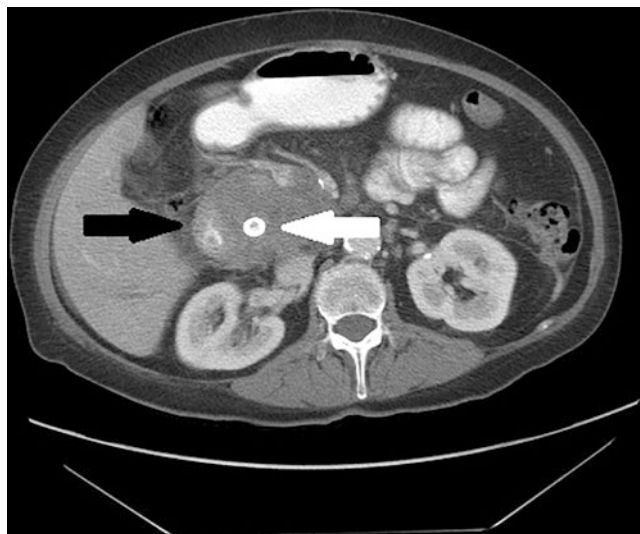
CT image demonstrating a locally invasive pancreatic cancer causing narrowing of the duodenum (*black arrow*) and bile duct obstruction requiring metallic stent placement (*white arrow*)
